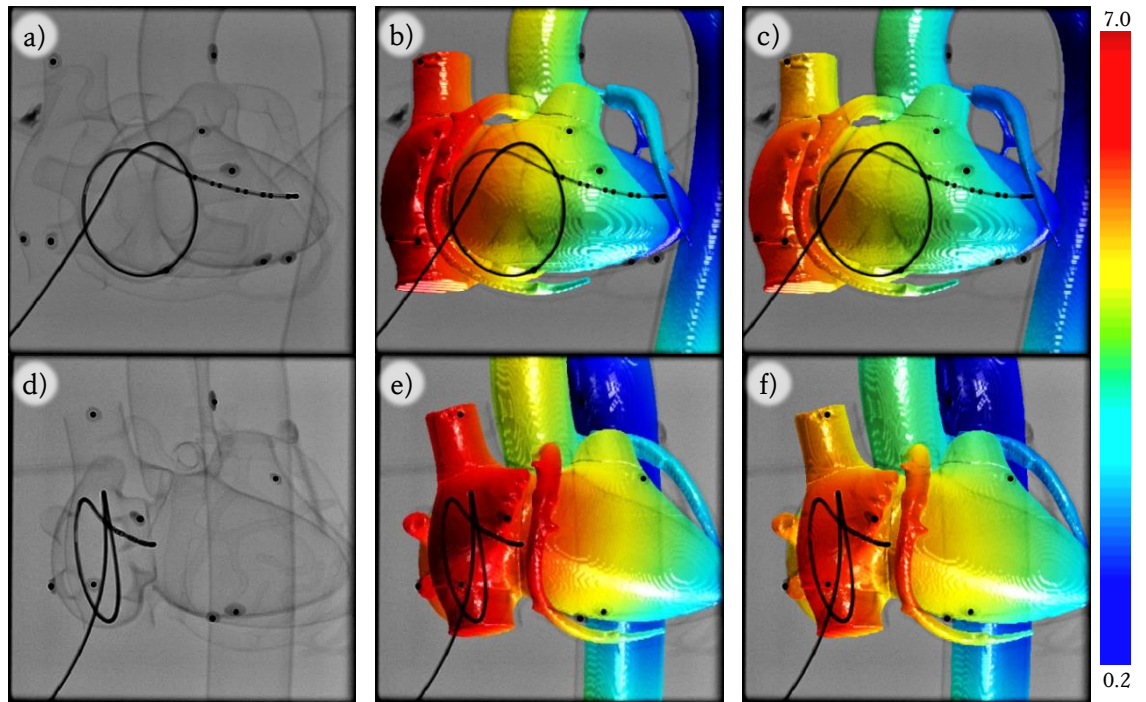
Visual representation of registration results using the b, e) biplane 1×BNHC strategy and c, f) the biplane 2×BNHC strategy applied to the first looped catheter configuration. Colour mapping of the CT data surface rendering shows the spatial distribution of 3D-TRE. The data is overlaid onto X-ray in a, b, c) PA and d, e, f) RAO 45° views.
